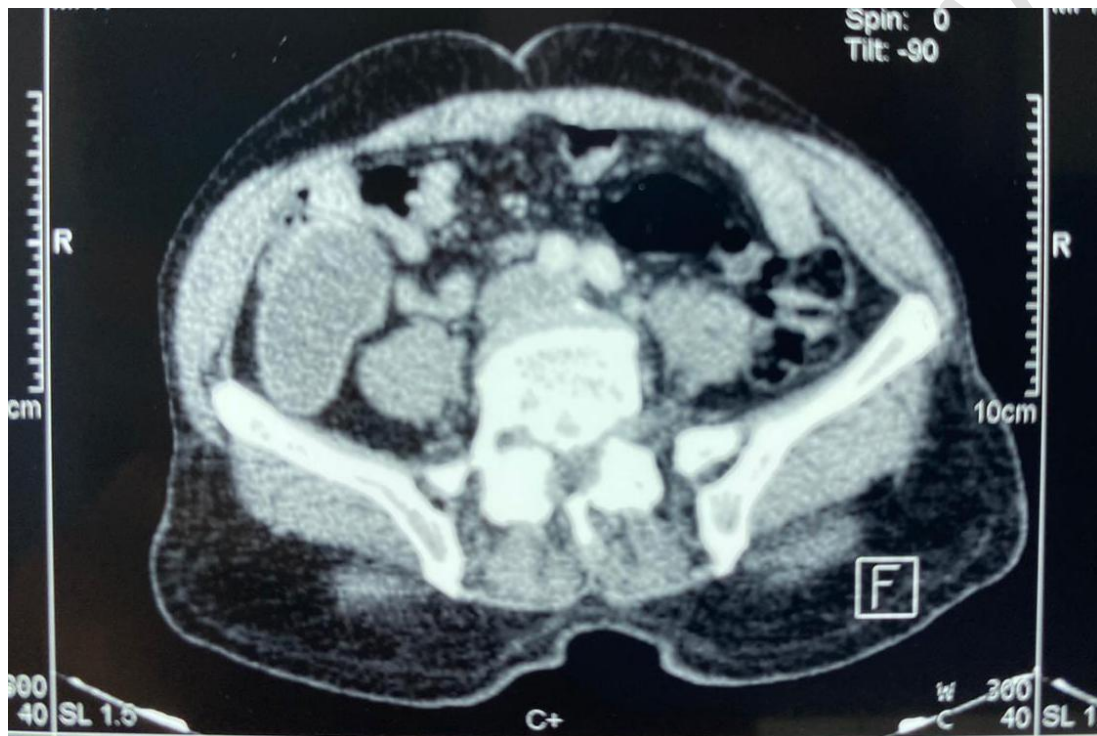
Abdominal CT in axial section after IV injection of the contrast product
